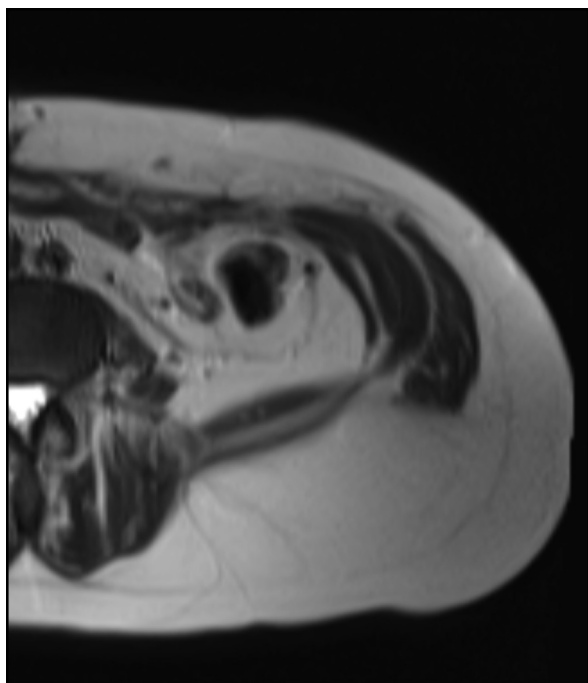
Magnetic resonance imaging of the abdomen showing evidence of a complete abdominal components separation. The external oblique is retracted laterally and its axis is oriented differently than the internal oblique and transversalis. The internal oblique shows significant hypertrophy.
